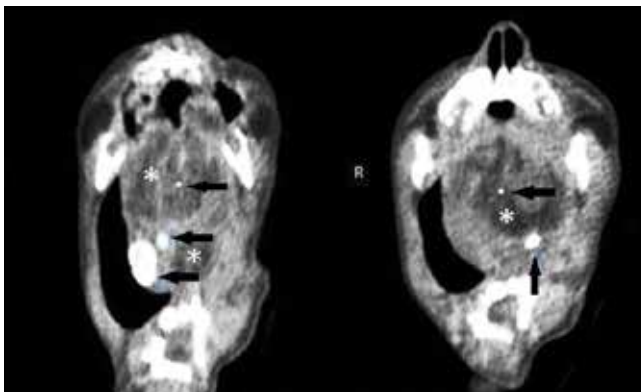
Non-contrast CT appearance before operation
